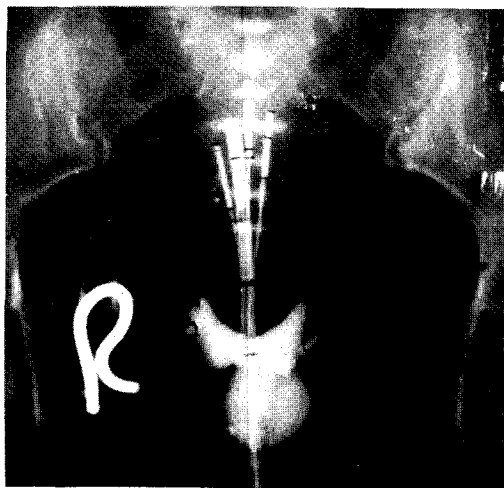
Anterior-posterior radiograph showing; Heyman capsules, tandem and ovoids.
